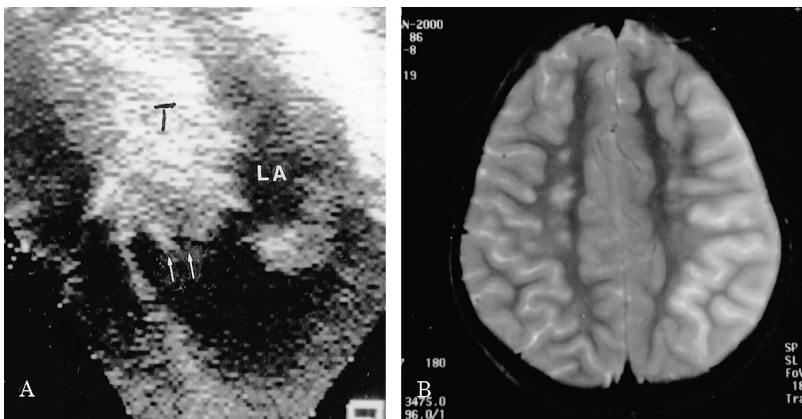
(A) Cardiac echocardiogram shows a large tumor (T) in the left atrium (LA) that crosses the mitral valve. Note the irregular surface on the left ventricular side of the tumor (arrows). (B) MR (repeat time 3475; echo time 96; TA 3:12) shows a large left middle cerebral artery infarction. There are also small punctate lesions at the gray/white junction and in the white matter of the right hemisphere.
